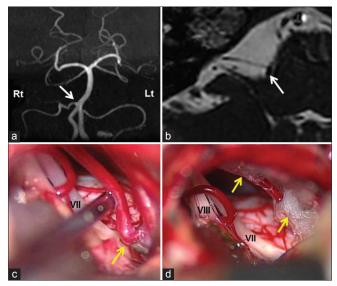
Case 5 (a) magnetic resonance angiography showing the origin of the right anterior inferior cerebellar artery from the distal vertebral artery (arrow) and short basilar artery, (b) axial three-dimensional fast imaging with steady-state acquisition magnetic resonance imaging showing the right anterior inferior cerebellar artery (arrow) compressing the root exit zone, (c) intraoperative photograph of the site compressed by the right anterior inferior cerebellar artery (arrow) intraoperative photograph, (d) the right anterior inferior cerebellar artery is transpositioned and fixed to the dura mater with two Teflon slings (arrows) and fibrin glue
